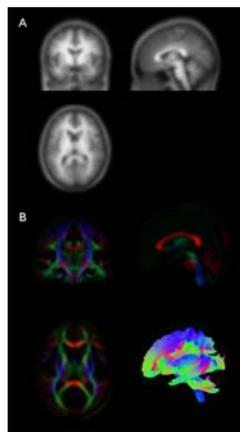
For spatial normalization, the MNI T1-weighted template (A) was used for the original approach, whereas for the new approach, a population-based DTI atlas was generated.
